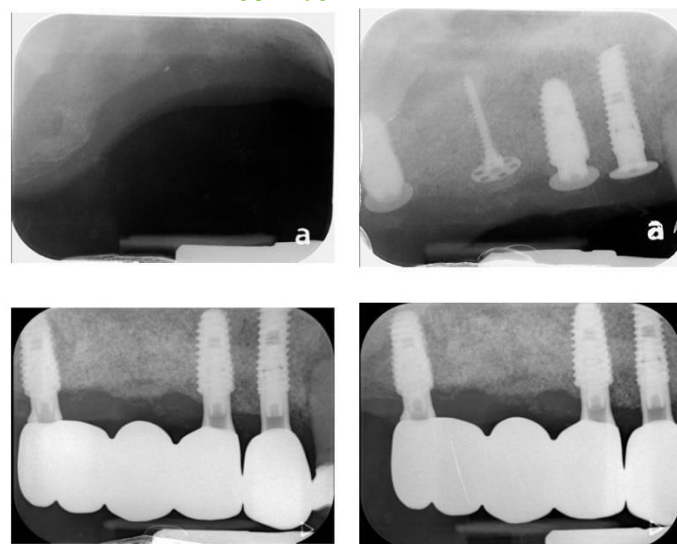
Radiographic evaluation throughout treatment and follow-up.
